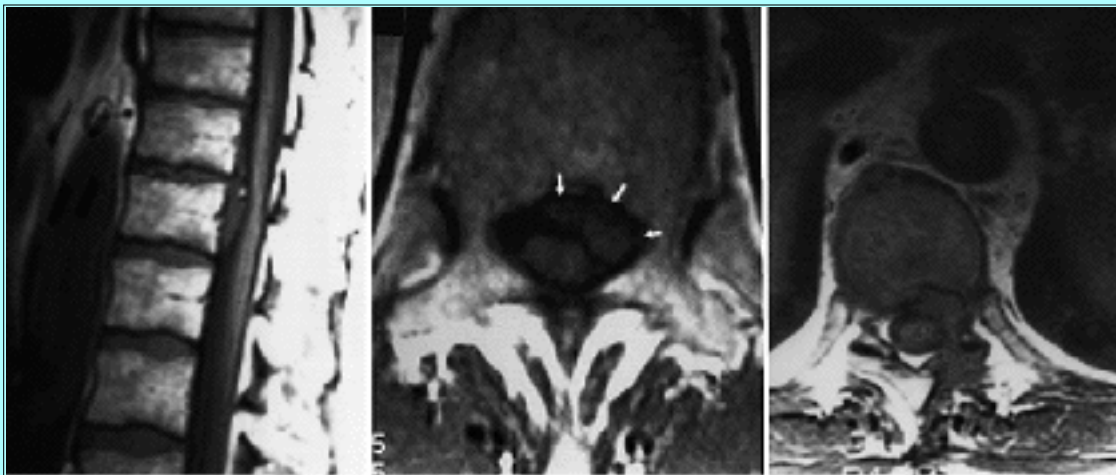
Case 3. Magnetic resonance (MR) images revealing a large extruded T10-11 disc in a patient presenting with pain and myelopathy. Left: Preoperative T₁-weighted sagittal MR image demonstrating a large ventral lesion with dorsal displacement of the spinal cord. Center: A T₁-weighted axial view. The ventral spinal canal is nearly entirely occupied with the disc. Arrows depict the extruded disc. Right: Postoperative gadolinium-enhanced MR image, axial view, obtained to assess the extent of disc removal. No intracanalicular disc material is present, and only normal postoperative changes are seen. The spinal cord has returned to its normal location and configuration.
